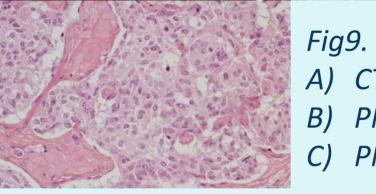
Insulinoma A) CT abdomen
